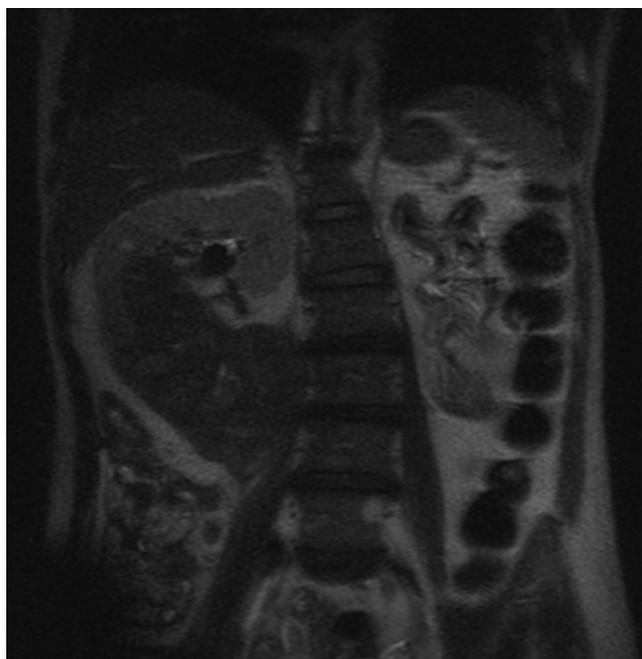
Coronal T2-weighted sequence showed a predominantly T2-hypointense, irregular mass in the lower pole of the right kidney invading the right psoas muscle.
